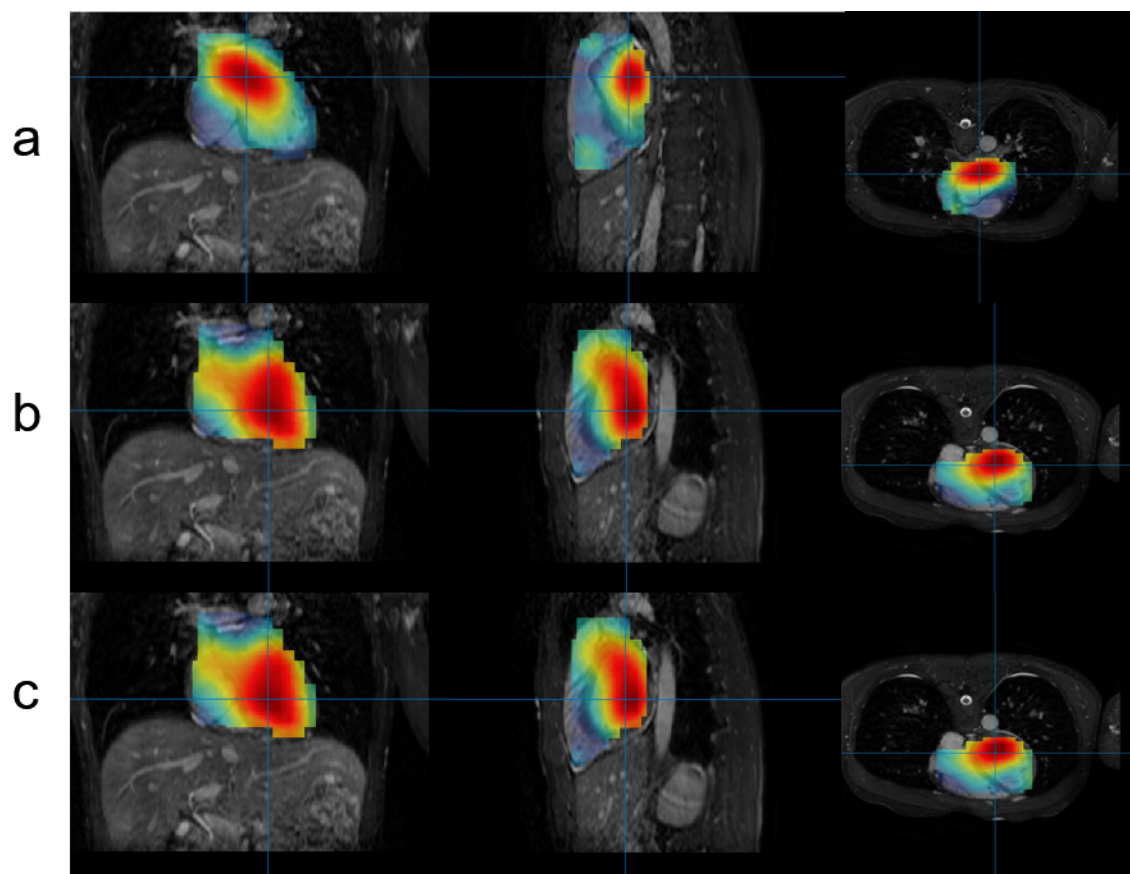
The source imaging results from the second dataset using LORETA, STKF, and ssGARCH-STKF. a. LORETA, b. STKF, and c. ssGARCH-STKF. The source activity results are superimposed on the MRI to show the heart activity at the P-point in accordance with the heart anatomy.
